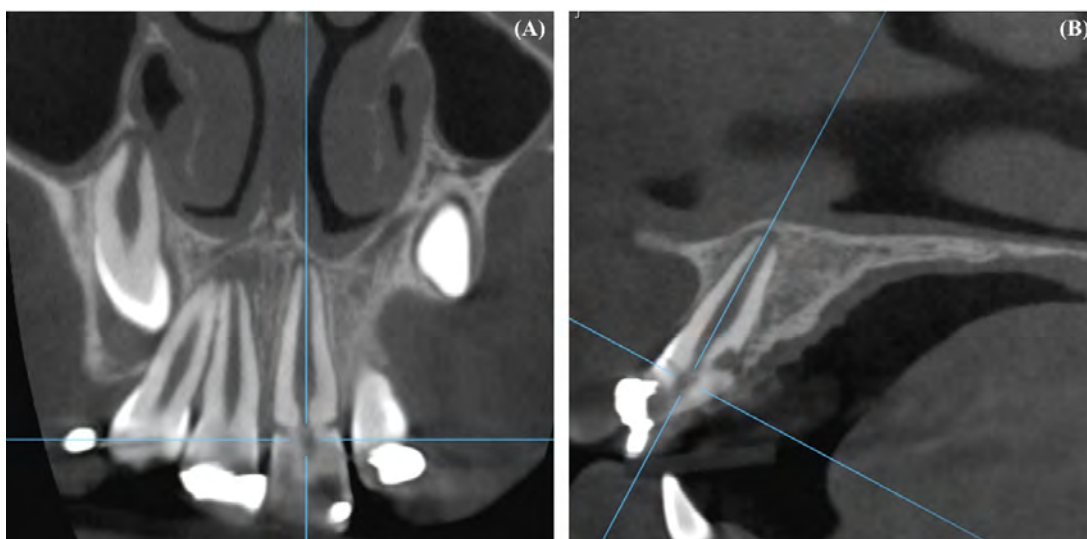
Image obtained by CBCT after 6 months of follow-up at the Dental Trauma Clinics at FORP/USP. Note in figure (A), in tooth 11, an increase in the radiolucent region suggestive of periapical lesion. In (B), in tooth 21, there is a decrease in the radiolucency of the fracture line through the vestibular surface and a probable healing of the connective tissue and new cement formation between the fragments through the lingual surface
